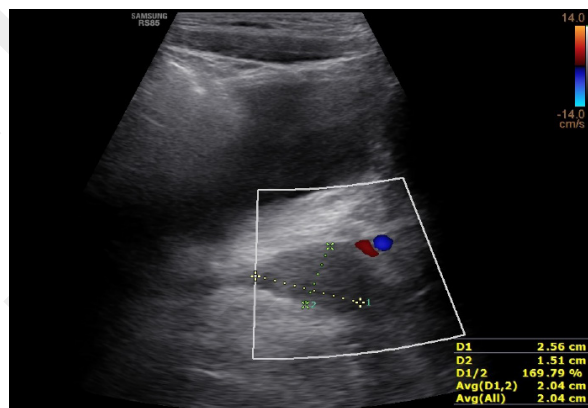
Patient No. 2. Abdominal ultrasonography revealed a solid, oval-shaped mass measuring 25 × 15 mm in the distal sigmoid colon
